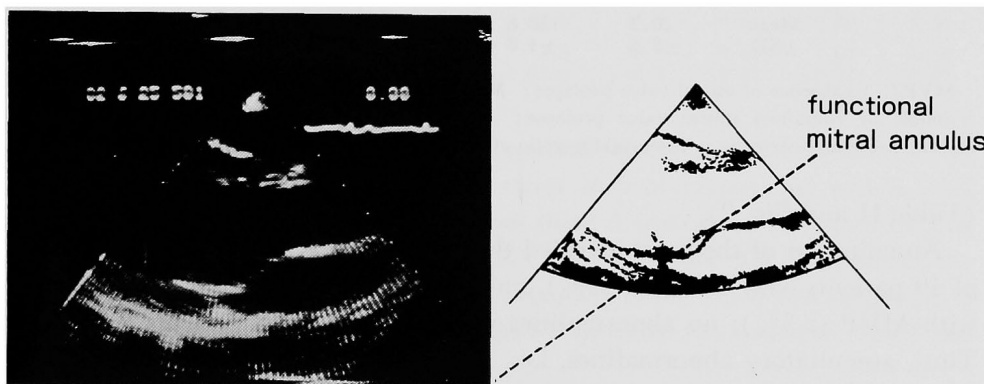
A typical long-axis view of the 2-D echocardiogram of mitral valve prolapse of the anterior leaflet (case No. 12).
